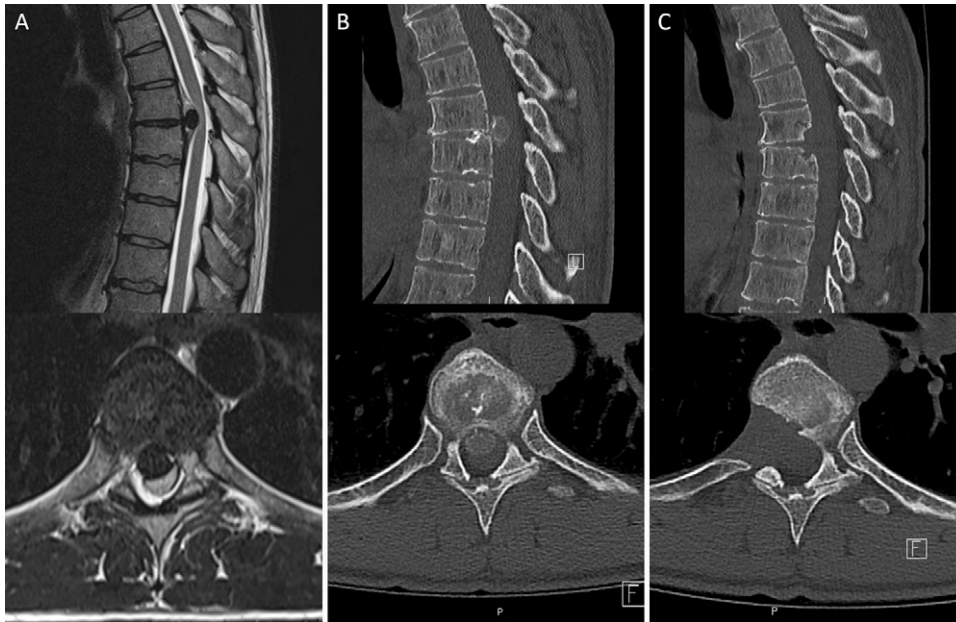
Case 4. A: Preoperative sagittal (*upper*) and axial (*lower*) T2-weighted MRI shows the central disc prolapse with effacement of the thecal sac and moderate cord compression. B: Preoperative sagittal (*upper*) and axial (*lower*) CT shows calcification of the disc prolapse extending into the spinal canal. C: Postoperative sagittal (*upper*) and axial (*lower*) CT shows the partial corpectomy and bony access with decompression of the spinal canal.
